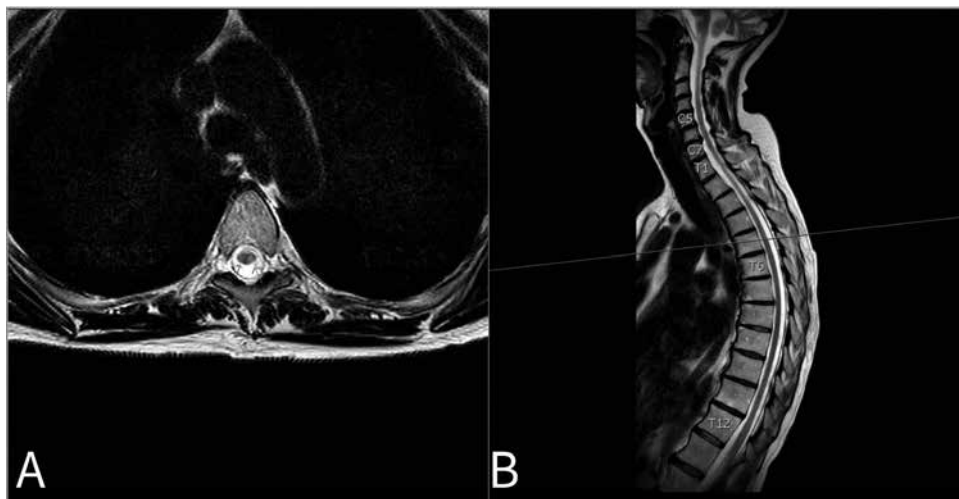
MRI of thoracic spine in patient with MS. Imaging at the T5 level demonstrates a single demyelinating plaque involving the left hemicord.
